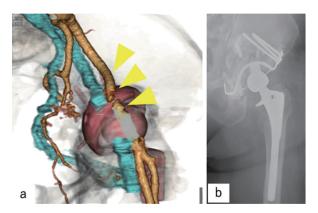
Case 3. a. Anteromedial view of the left pelvis on 3D CT angiography. The external iliac artery (beige line) and external iliac vein (blue line) were compressed and shifted superiorly by the edge of the migrated cup (yellow arrowhead). b. Postoperative anteroposterior left hip radiographs.
